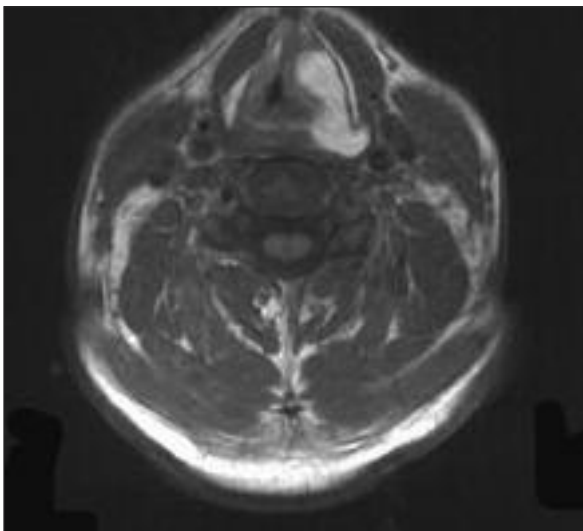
The hyperintense appearance secondary to the lipoma is seen on axial T1 weighted MR image obtained at the same level.
